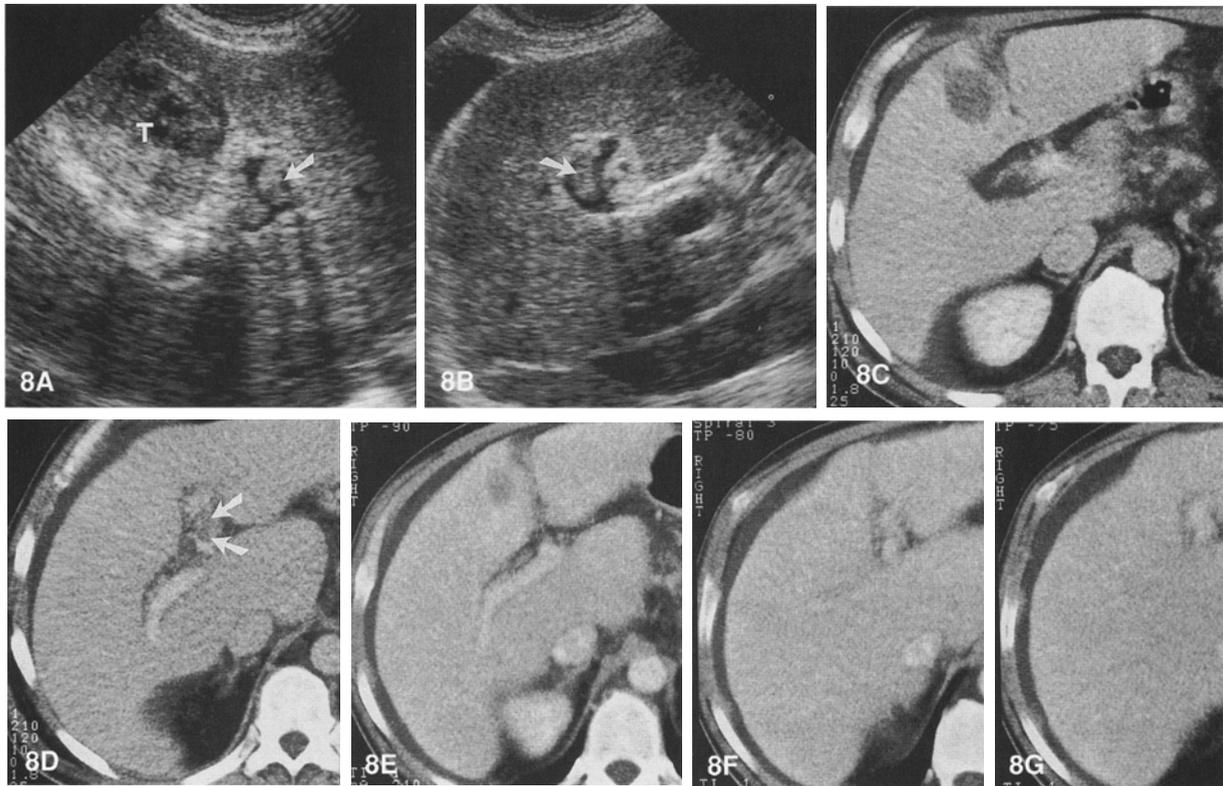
Chemical portal vein thrombus following US-guided PEI. Patency of the portal vein had been documented before US-guided PEI in this patient with a HCC in segment 4, adjacent to the left portal vein. The axial US image A and the sagittal image B were obtained 24 hr after PEI and show the tumor (*T*), and a solid thrombus in the left portal branch adjacent to the tumor (arrows). C, D These contrast-enhanced spiral CT images were obtained 6 days after US-guided PEI, and confirm the presence of a solid floating thrombus in the left main portal branch (arrows). E–G Contrast-enhanced spiral CT was repeated 4 months later. At this time, the tumor has decreased in size E, and the thrombus has disappeared (F, G).
